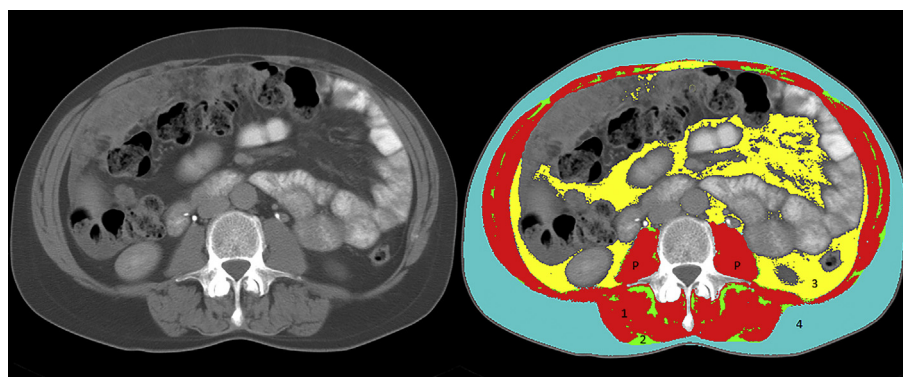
Computed tomography assessment of skeletal muscle and adipose tissue with SliceOmatic software. Preoperative axial computed tomography (CT) scan of an ovarian cancer patient. Both images are taken from the same patient. On the left a regular CT image at the level of the third lumbar vertebra. On the right an image coloured using SliceOmatic software. 1 = skeletal muscle, 2 = intramuscular adipose tissue, 3 = visceral adipose tissue, 4 = subcutaneous adipose tissue, P = psoas muscle.
